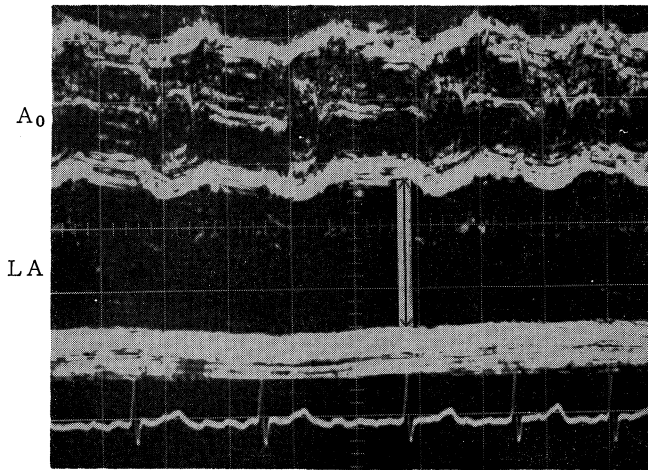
An echocardiogram showing how to measure left atrial dimension (arrow). Ao=aortic cavity, LA=left atrial cavity.
